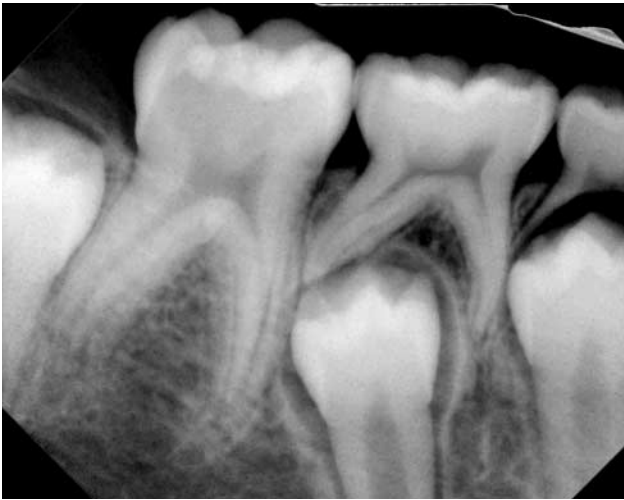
Preoperative radiograph of case no. 2.
